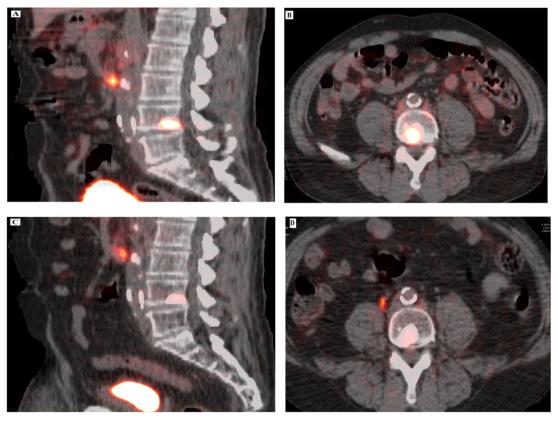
PSMA-PET/CT scans of a patient with prostate cancer. (A) Pre-SBRT sagittal section, (B) pre-SBRT axial section, (C) post-SBRT (3 months after SBRT) axial section with partial response, (D) post-SBRT sagittal section.
